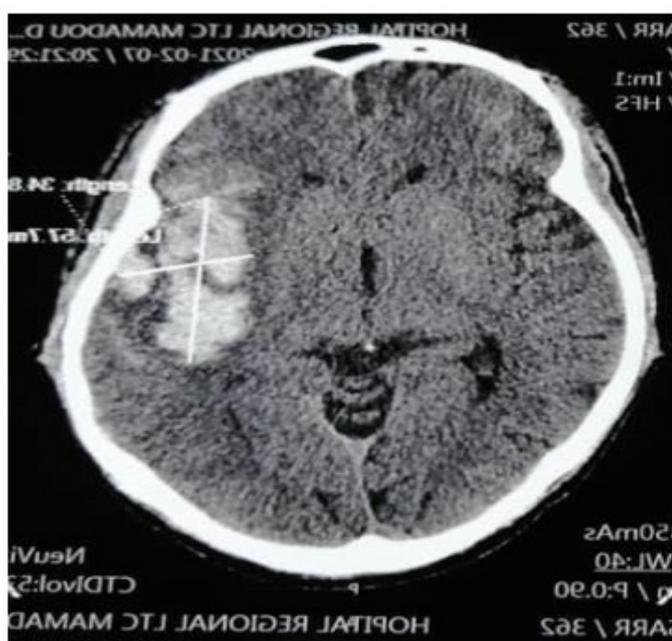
Cerebral CT: Left temporal parietal haematoma.
